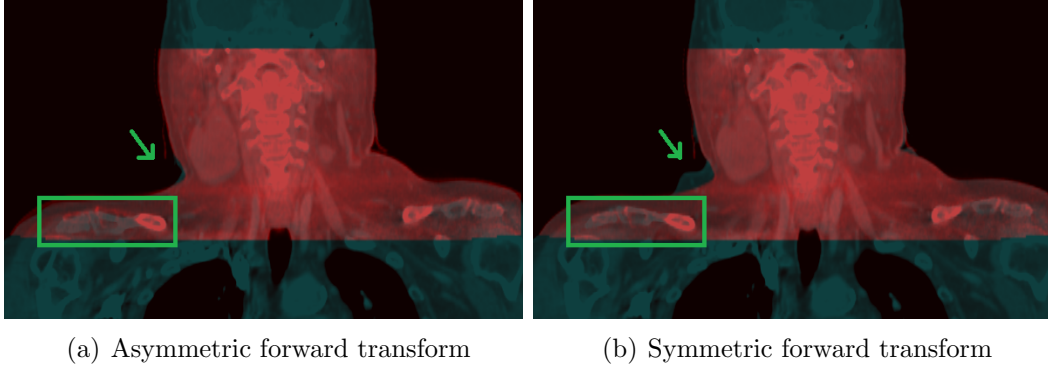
Coronal plane images of patient Z showing an overlap between CBCT (red) and deformed pCT (cyan). Registration was performed using an (a) asymmetric and (b) symmetric transform. Soft tissues are better aligned during asymmetric registration (green arrow) and bone structures are better aligned during symmetric registration (green square).
